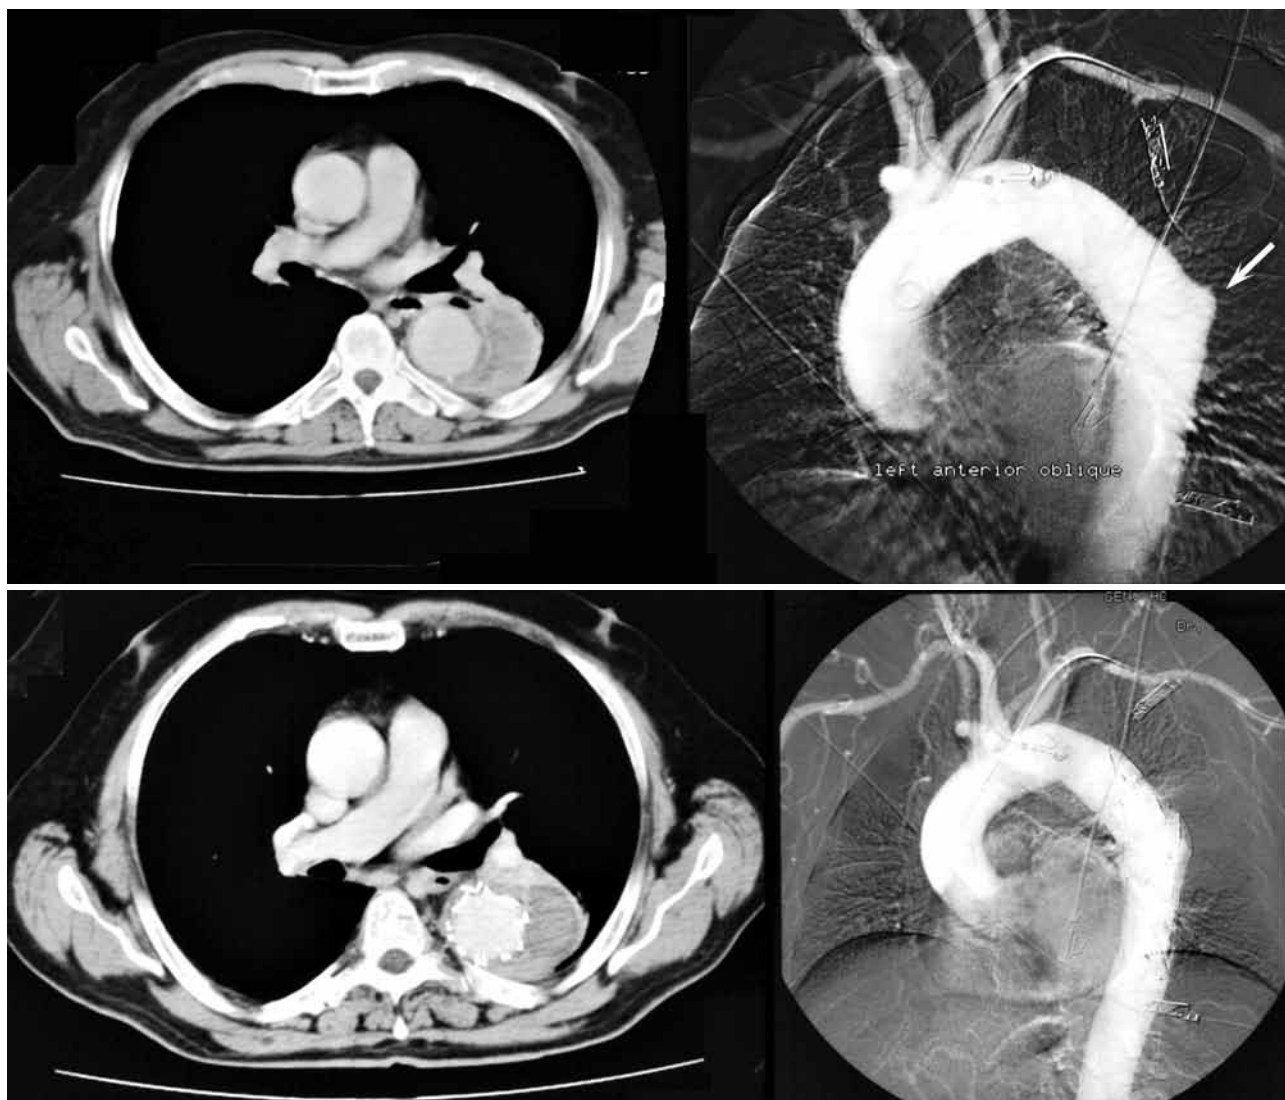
Penetrating aortic ulcer; computed tomography angiography (CTA) pre (upper panels, arrow) and post (lower panels) endovascular repair.
